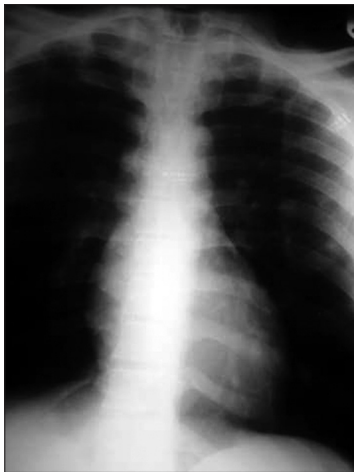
(X-ray at presentation)
